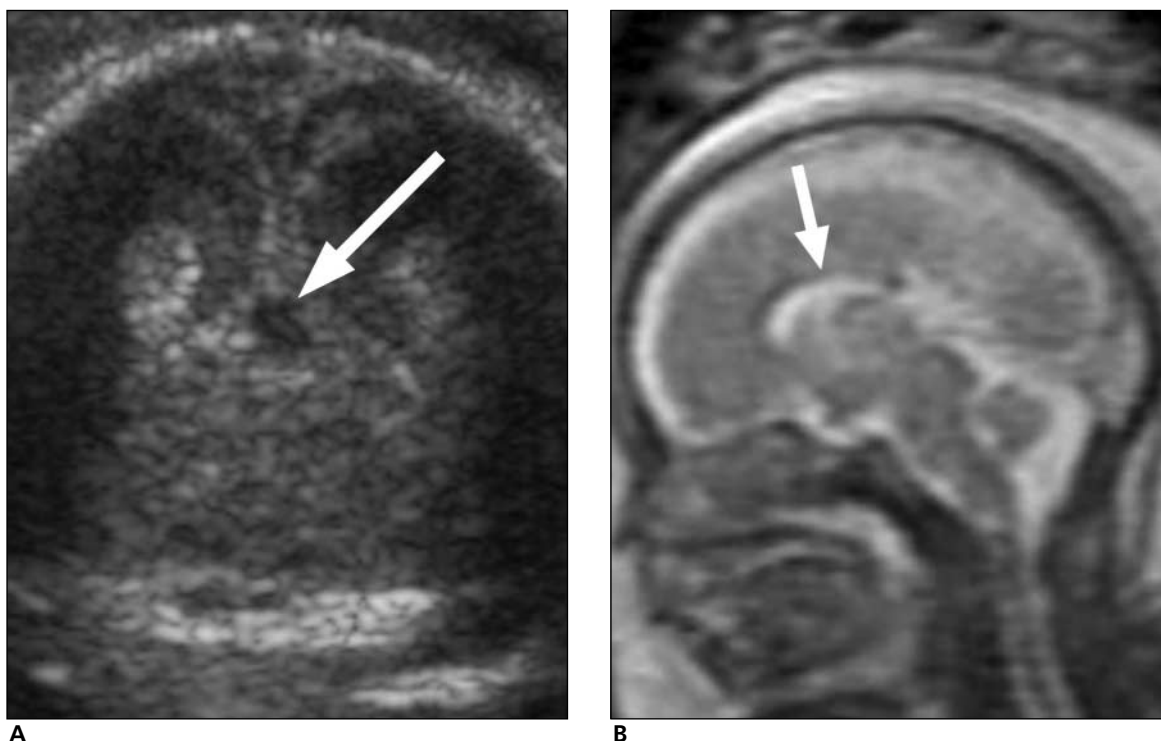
Images from a fetus at 20 gestational weeks with a suspected callosal abnormality on sonography (case 9). A, Coronal sonogram showing a midline dorsal cyst (arrow) at 19 weeks' gestation. Only the anterior corpus callosum was visualized on other images. B, Sagittal SSFSE T2-weighted image showing an intact corpus callosum (arrow) on MRI performed at 20 weeks' gestation.
